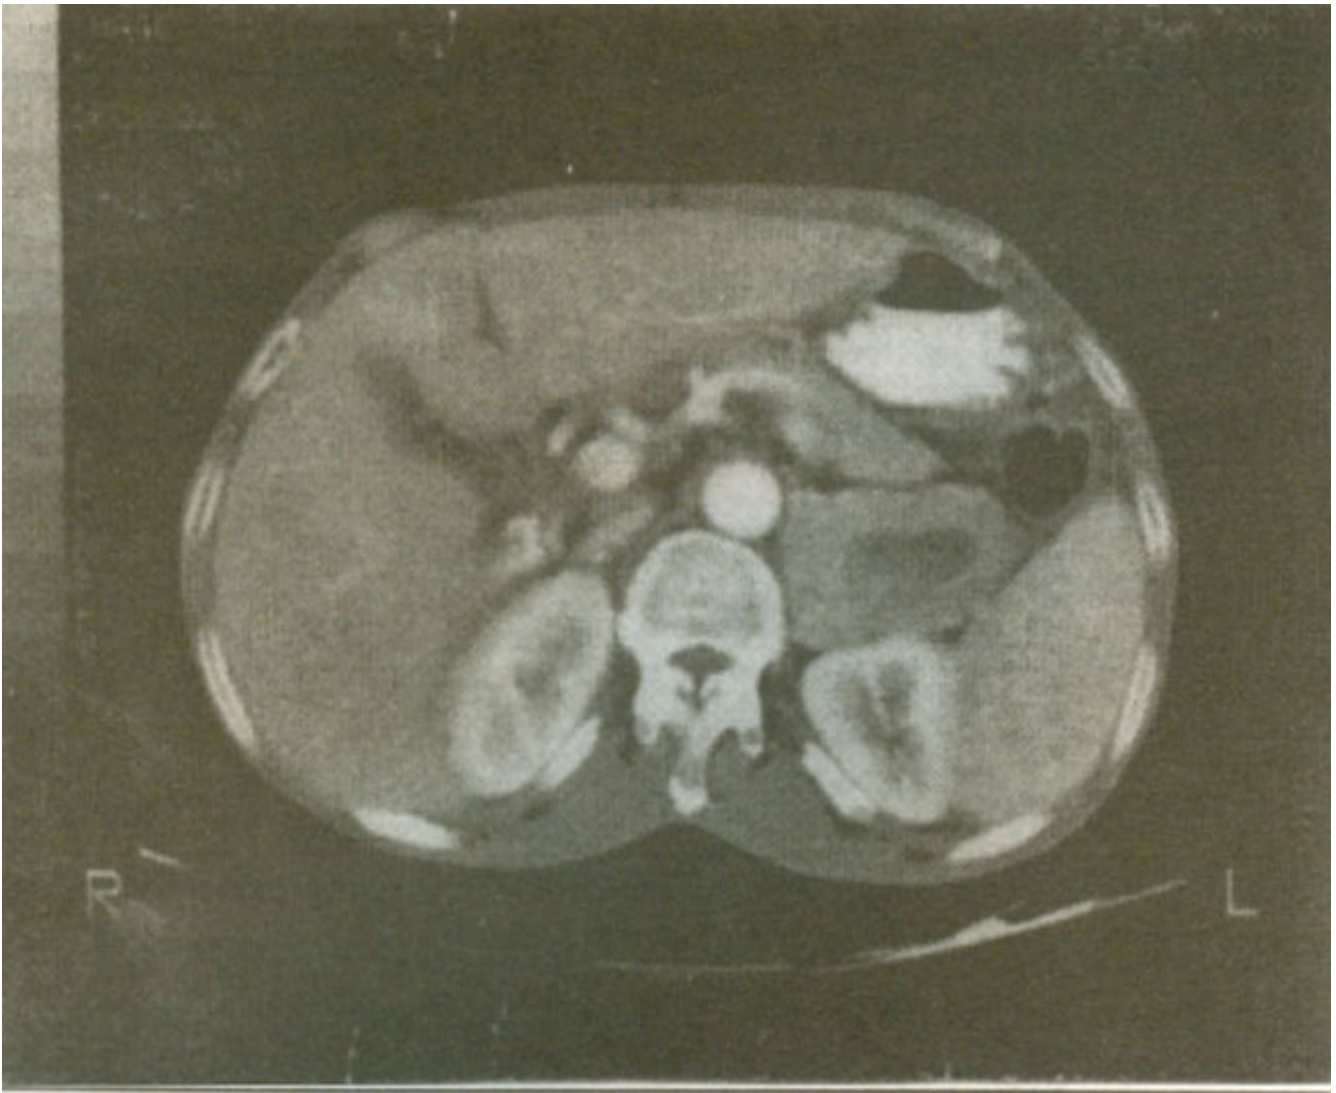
CT scan of the abdomen showing left supra-renal with necrotic center
